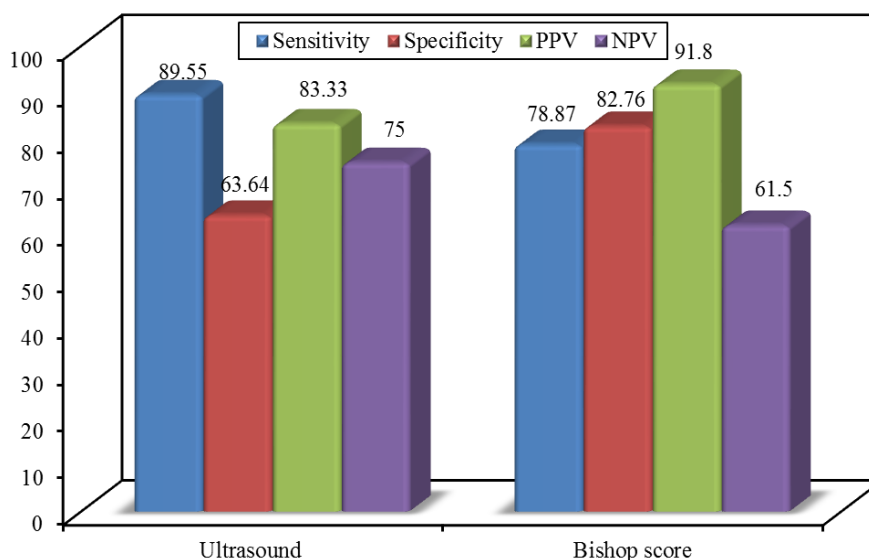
Comparison between ultrasound and bishop score
